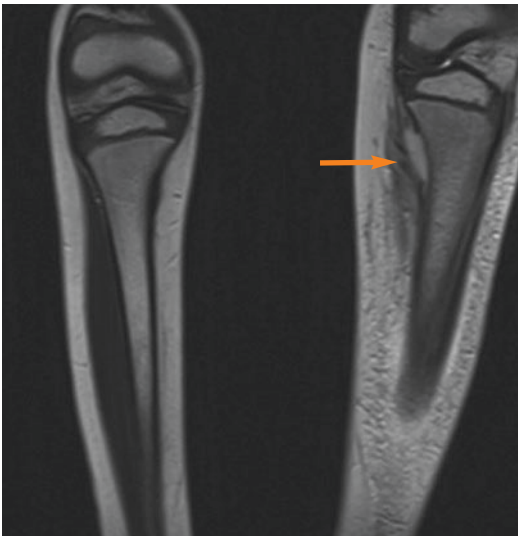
MRI of both lower legs. Subperiosteal abscess on the medial side in the proximal part of the tibia (*arrow*)
